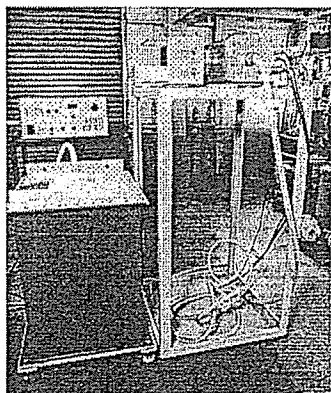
General view of The 100 kV stroboscopic x-ray generator.
